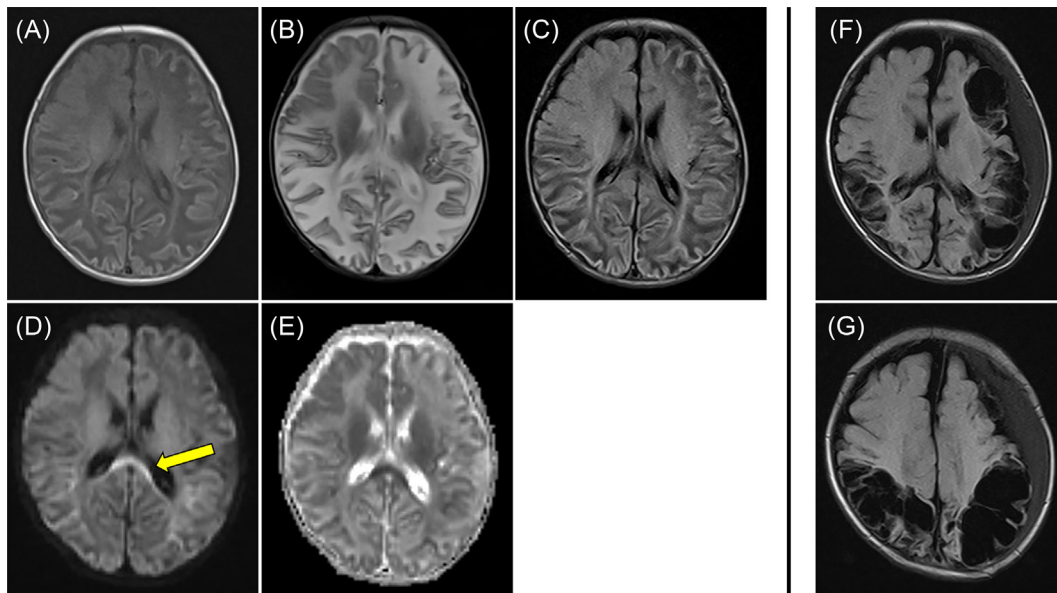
Brain MRI on day 14 revealing hypo-intensity on T1 (A) and fluid-attenuated inversion recovery (C) sequence and hyper-intensity on T2 (B) in the deep and subcortical white matter of the left frontal, bilateral temporal to parietal lobes, and hyper-intensity on diffusion-weighted sequence (D) and decreased apparent diffusion coefficient value (E) in the corpus callosum (arrow). Fluid-attenuated inversion recovery sequence on day 45 revealing cystic cavitations in left cerebral hemisphere and right temporal, occipital, and parietal lobes and left epidural fluid accumulation (E, F).
